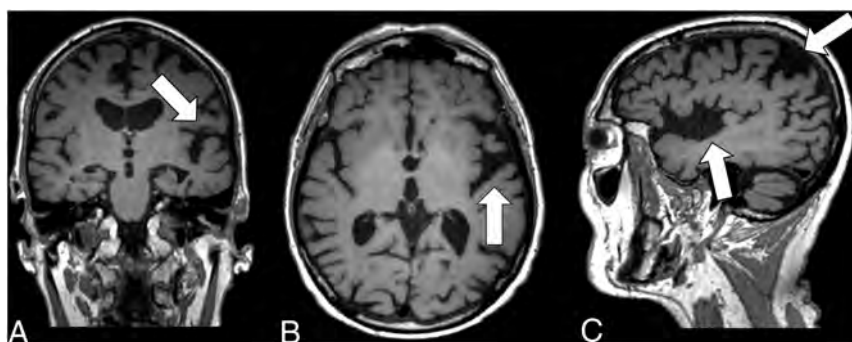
Coronal T1-weighted MR imaging (A), axial T1-weighted MR imaging (B), and sagittal T1-weighted MR imaging (C) in a right-handed individual with impaired repetition of phrases demonstrate asymmetric widening of the left Sylvian fissure with left posterior peri-Sylvian and temporoparietal atrophy (white arrows, A–C), suspicious for lvPPA.
